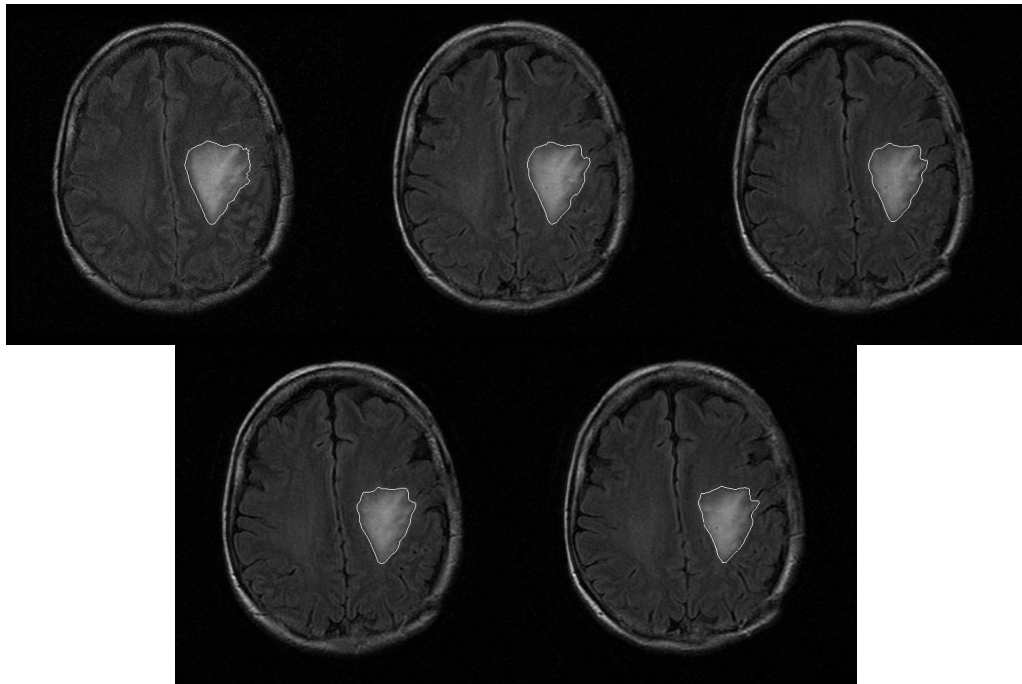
Examples of tracking results of Patient 1 in five examination periods (FLAIR images)
